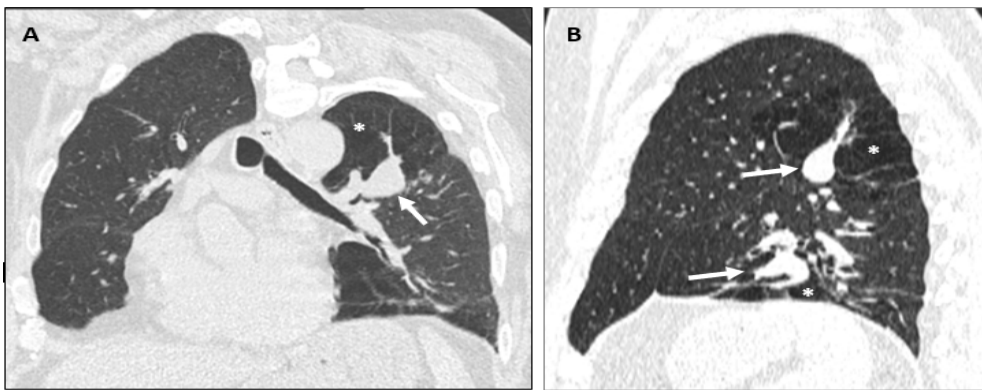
Chest CT reformatted coronal oblique (A) and sagittal oblique (B) images depicting branching tubular opacities (white arrows) that do not communicate with the bronchial lumen on the superior segment and medial basal segment of the left lower lobe. Focal oligoemic areas of the adjacent lung parenchyma (*) extend to the left upper lobe apicoposterior segment due to an incomplete left major fissure.
